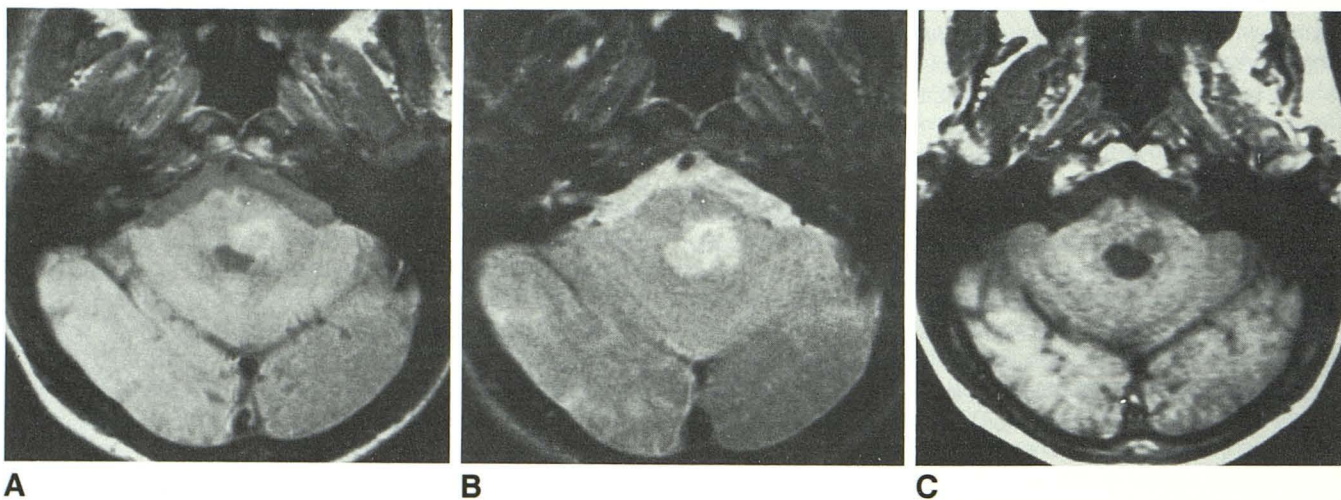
A–C, Case 6. 51-year-old man with AIDS presenting with a brainstem lesion. Proton density and T2-weighted images 3000/30, 80 (A and B), 600/20 (C), show a small, slightly hyperintense lesion relative to gray matter in left pons with moderate edema and mild mass effect. On the T1-weighted image, tumor appears hypointense relative to gray matter.
